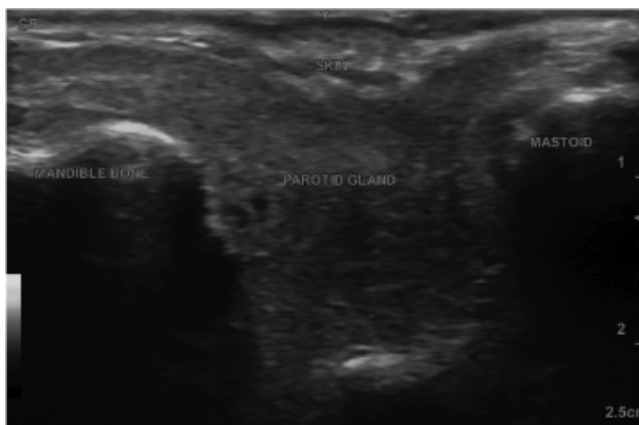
Parotid gland (periauricular portion). The facial nerve lies midpoint in depth within the parotid gland, usually not visible on ultrasound yet accompanied by visible vascular structures.
